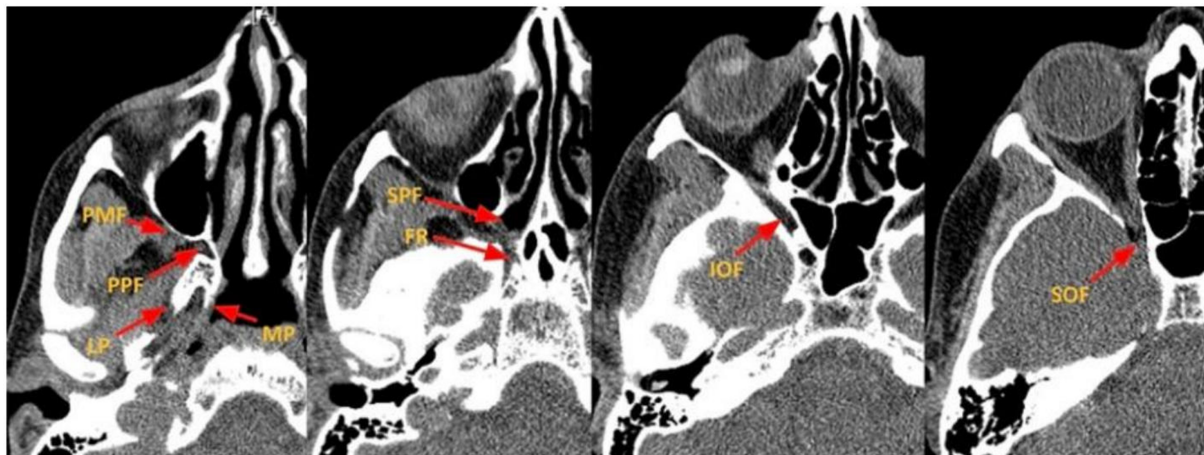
Axial CT images depicting the key components of the PPF and skull base foramina. PPF: Pterygopalatine fossa; PMF: pterygomaxillary fissure; LP: lateral plate of the pterygoid; MP: medial plate of the pterygoid; SPF: sphenopalatine foramen; FR: foramen Rotundum; IOF: inferior orbital fissure; SOF: superior orbital fissure; CT: computed tomography.
